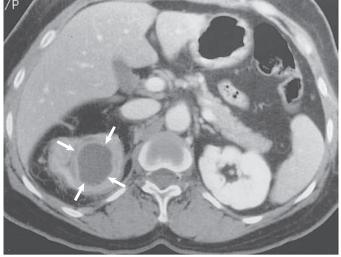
Xanthogranulomatous pyelonephritis. Contrast-enhanced CT scan with the inflammatory mass outlined by *arrows*. Pathologic diagnosis confirmed xanthogranulomatous pyelonephritis. (Courtesy W. Bush, University of Washington, Seattle, Wash.)
